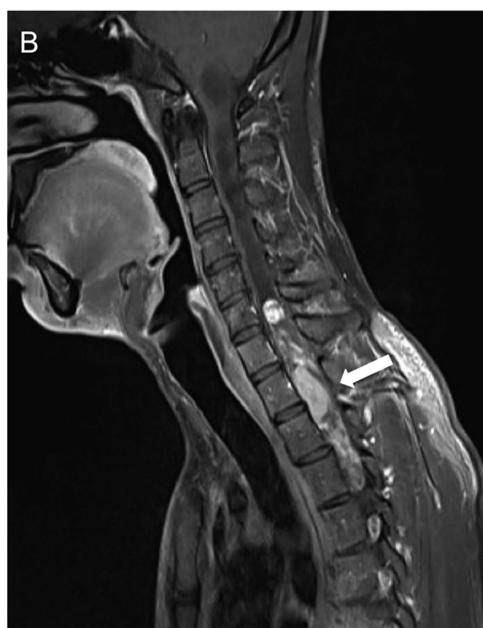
Sagittal MRI. The T1-weighted sequence (A) shows that the intramedullary lesion is isointense to the cord (thin arrow). On postgadolinium fat suppressed sequence (B), the lesion demonstrates heterogeneous and avid enhancement (thick arrow).
